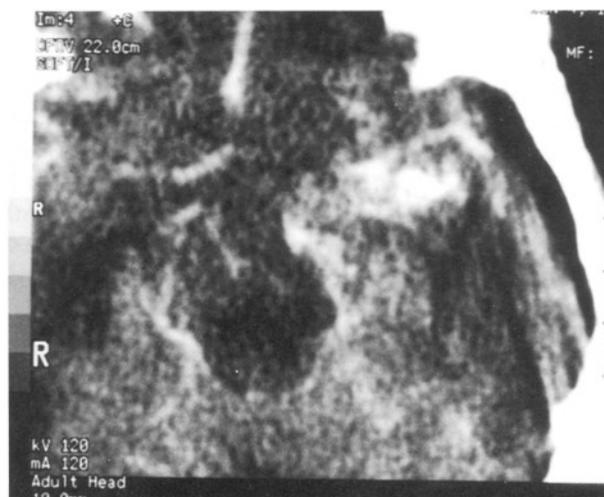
a. Preoperative CT scan demonstrating a large left perisylvian haematoma extending to the basal ganglia in a 56 year-old patient, b. Infusion CT scan which had been photographed at intermediate window showed a hyperdense filling on the left MCA branch. Patient immediately underwent simultaneous removal of haematoma and clipping of the aneurysm, which was located on the M2 segment of the left MCA.
